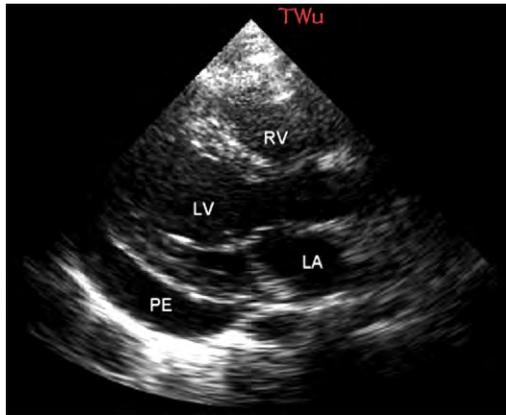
Parasternal view of a pericardial effusion.
